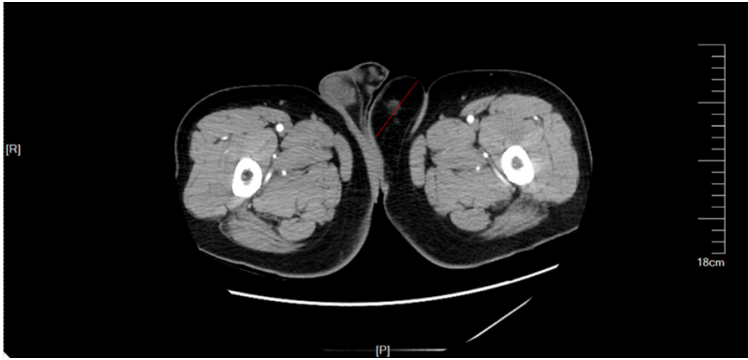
Contrast-enhanced CT image depicting a giant lipoma of the inguinal perineal area.
